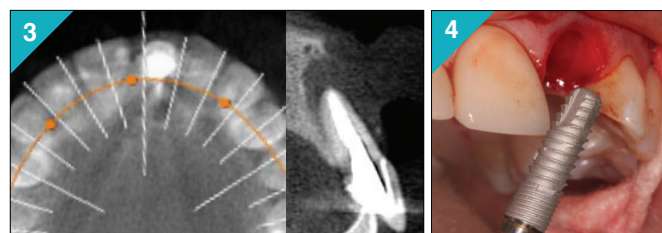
Cross-sectional CT of upper left central incisor.
